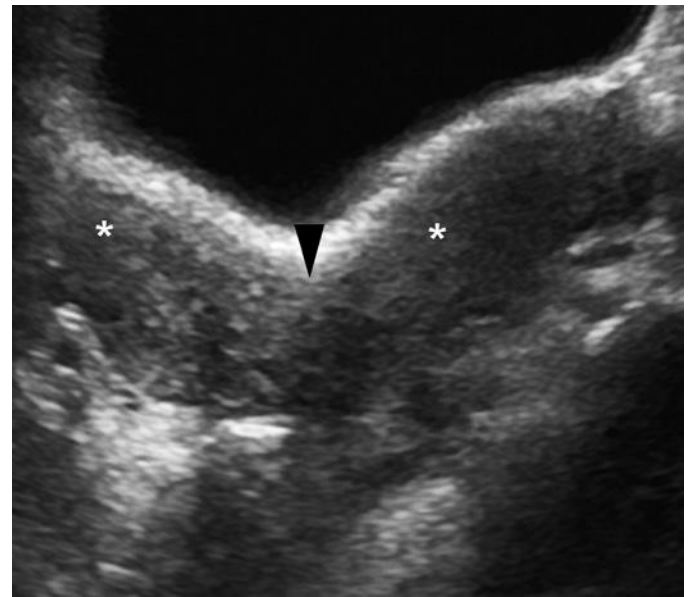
Bicornuate uterus in a 13-year-old girl. Transverse pelvic ultrasound image shows two uterine horns (*asterisks*) with a deep central depression of the external myometrial fundal contour (*arrowhead*). The right kidney was absent (not shown).
